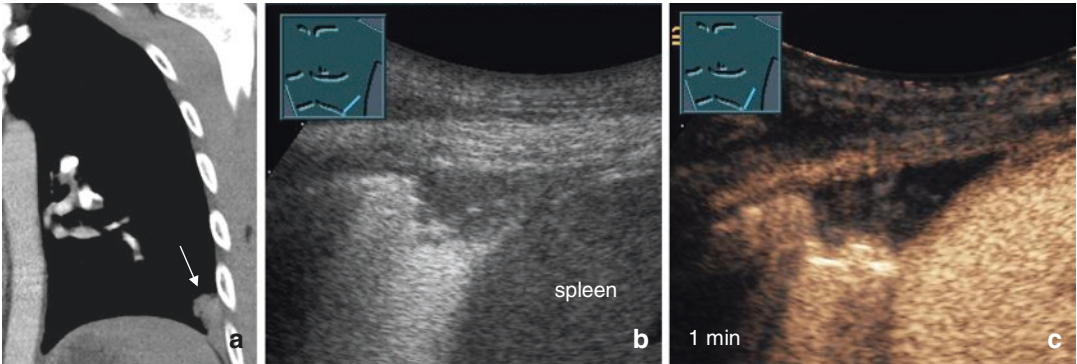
Patient with anamnestic tuberculosis and a marked pleural thickness on CT scan (a); B-mode imaging presents a hypoechoic pleural lesion (b); CEUS shows a marked enhancement with small areas of no enhancement (arrow) (c); US-guided pleural biopsy confirmed diagnosis of *active pleural tuberculosis*
